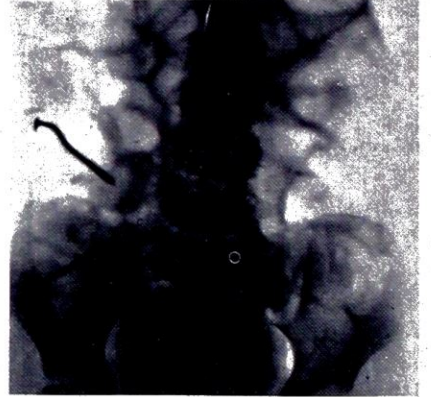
Radiograph of a nail impacted in the colon at the hepatic flexure. Removed by the technique shown in *Fig. 467*.
